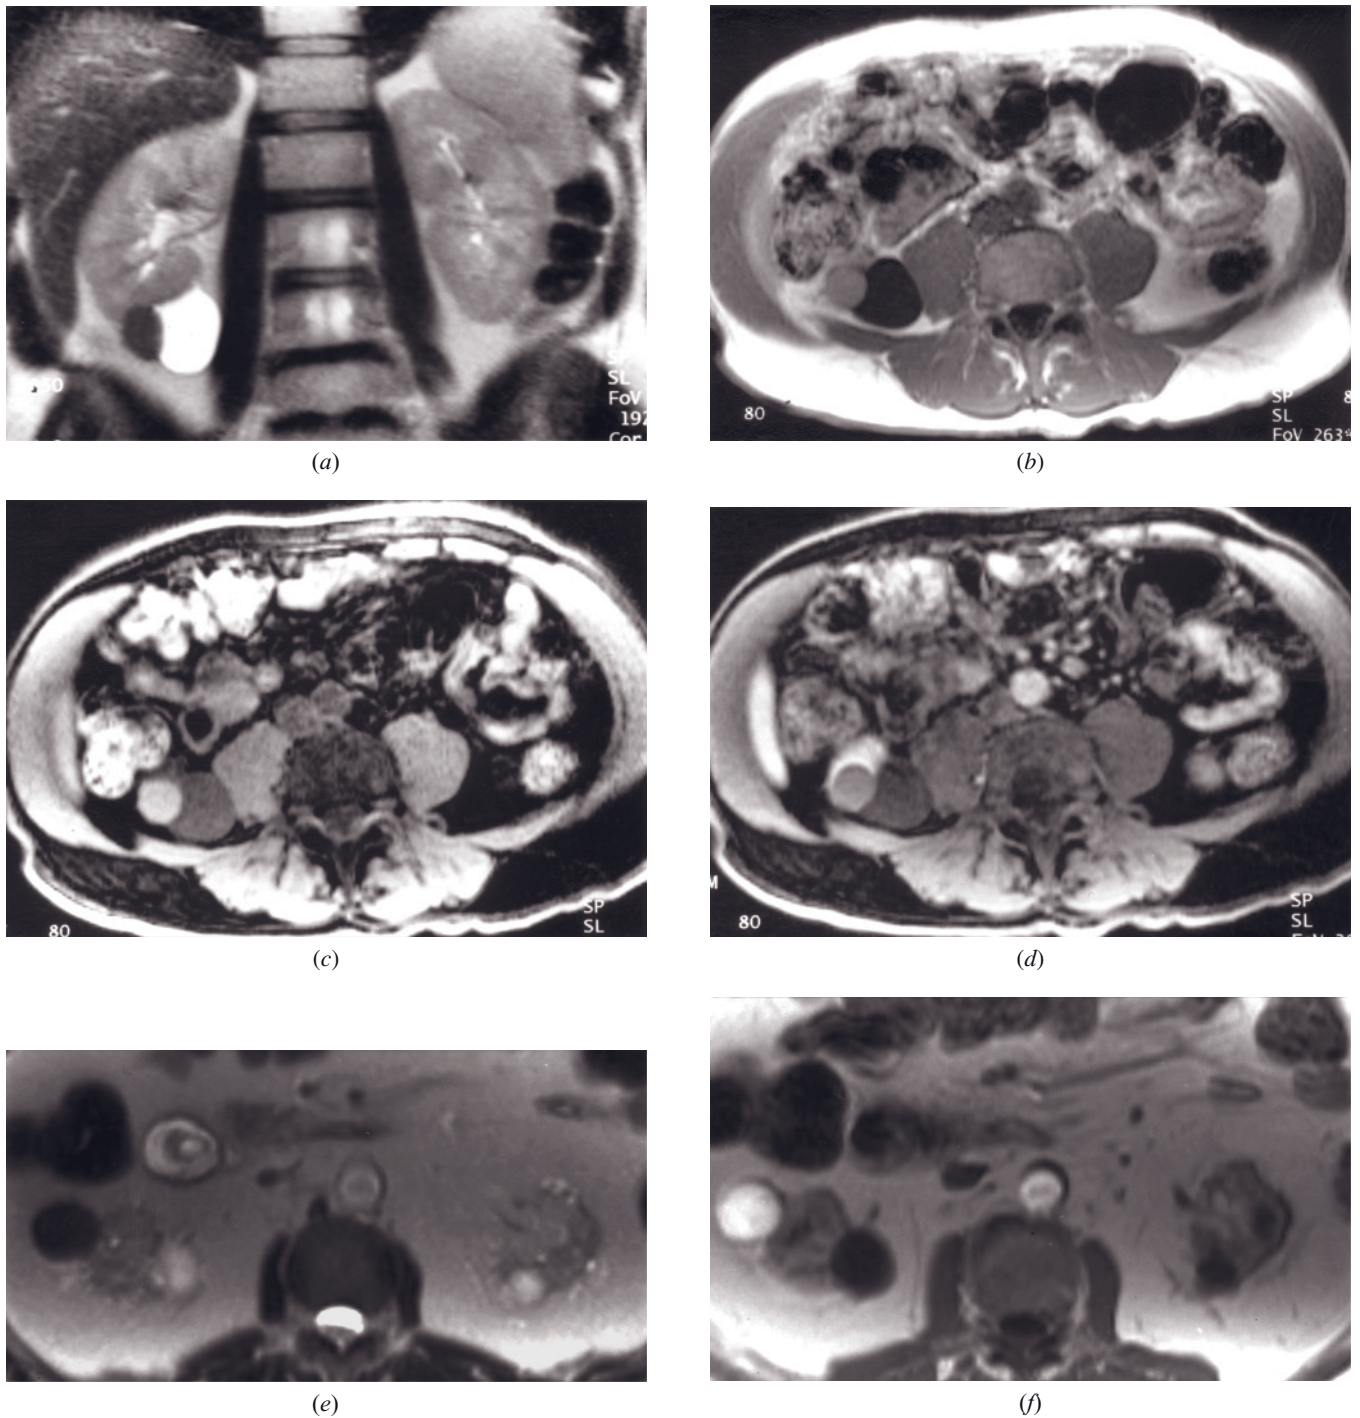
Simple and hemorrhagic cysts. Coronal T2-weighted SS-ETSE (*a*), transverse T1-weighted precontrast (*b*), precontrast fat-suppressed (*c*), and 90-s fat-suppressed postgadolinium (*d*) SGE images. Exophytic simple and hemorrhagic renal cysts are side by side, arising from the lower pole of the right kidney. The hemorrhagic cyst shows low signal intensity on T2-weighted image (*a*) and high signal intensity on T1-weighted precontrast images (*b*, *c*), signal behavior opposite to that of the simple cyst. T2-weighted SS-ETSE (*e*) and immediate postgadolinium SGE (*f*) images in a second patient show bilateral simple renal cysts and, at the same tomographic level arising from the lateral aspect of the right kidney, another cyst with low signal intensity on T2 (*e*) and increased signal on T1 (*f*)-weighted images, consistent with increased protein content or hemorrhage.
